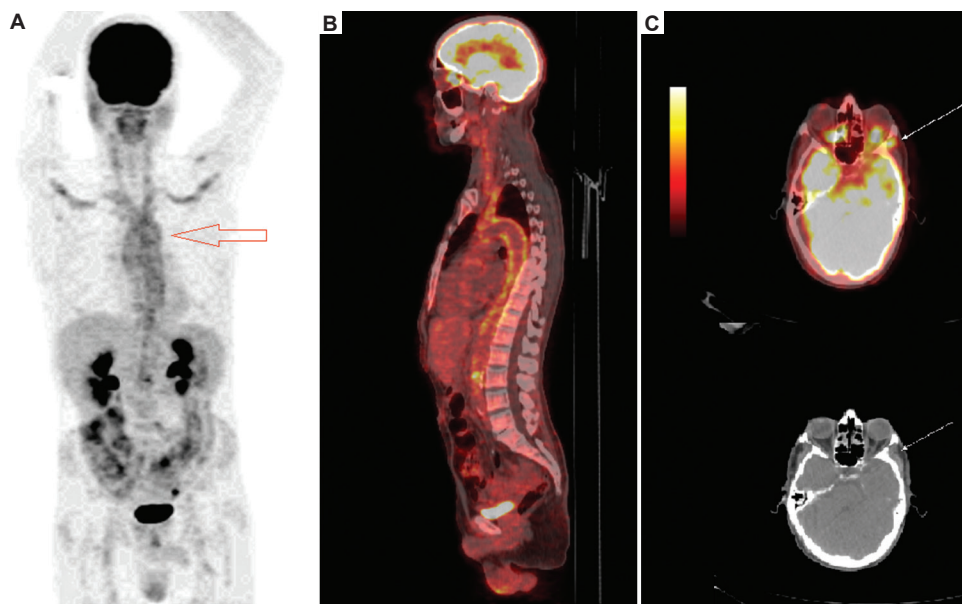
¹⁸F-FDG PET scan of a patient follow-up for suspected vasculitis. (A) Maximum intensity projection and (B) fusion image in the sagittal section showing moderate vascular hypermetabolism of the neck and mediastinum (SUVmax = 5.3) with a characteristic “crossbow appearance” (red arrow). (C) Fusion image in the axial section showing suspected hypermetabolic uptake in the left temporal artery (SUVmax = 4.5), compatible with Horton’s disease.
